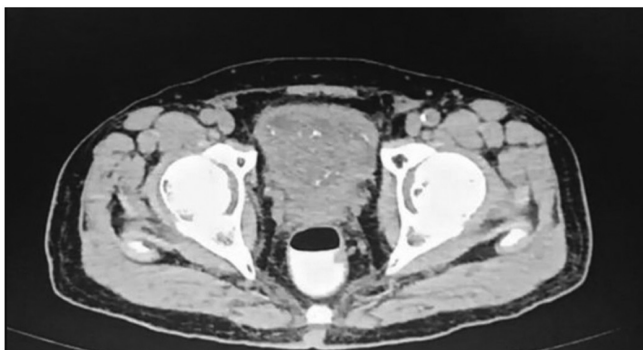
CT scan abdomen axial view showing diffusely thickened bladder wall and a fungating mass 6cm in widest AP diameter.
